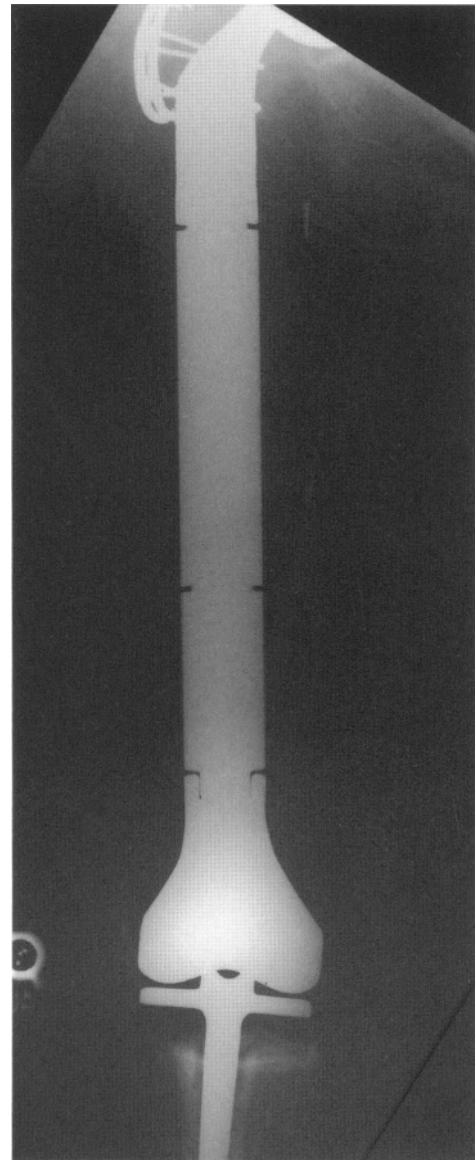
Postoperative radiograph showing the final total femur prosthetic reconstruction of the patient shown in Figure 29.6.
